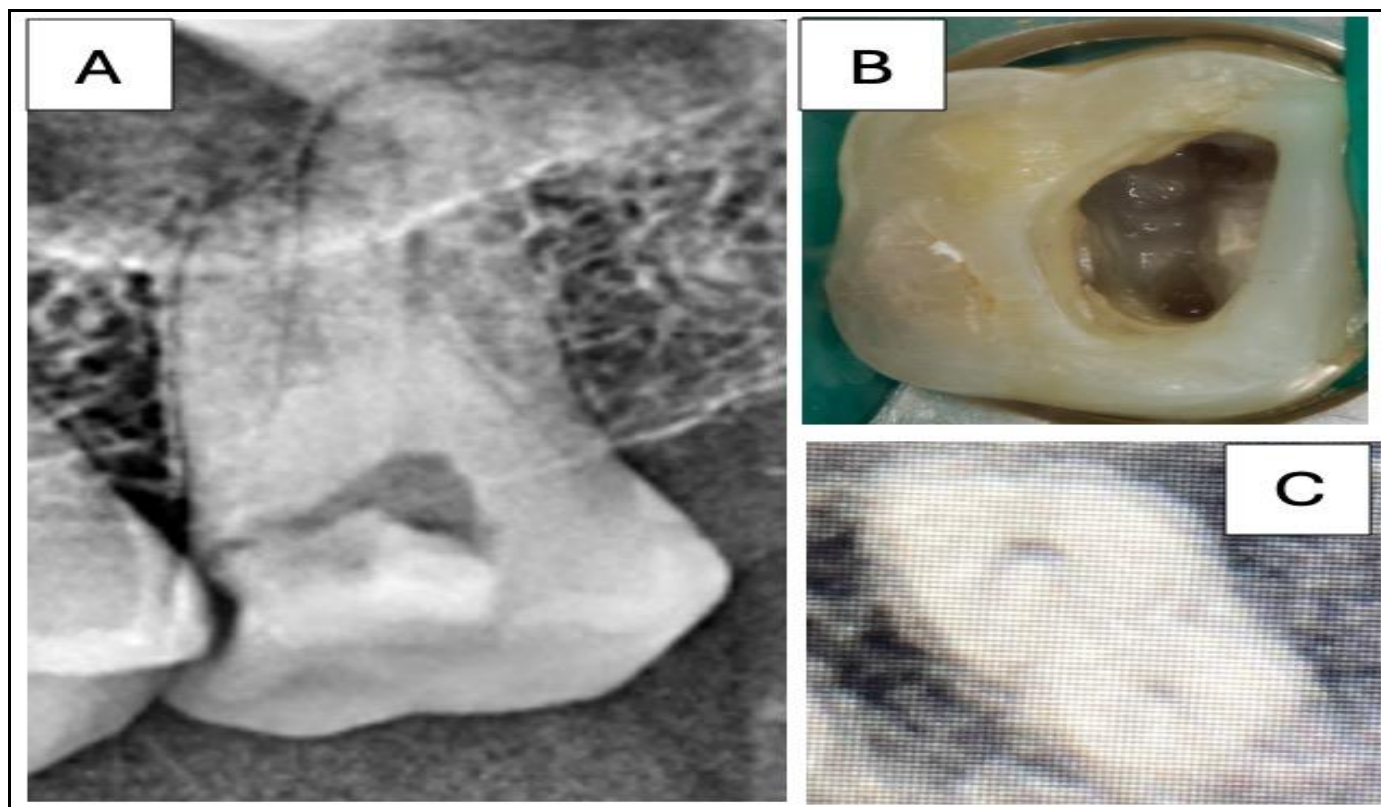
Pre-Operative. A: Intraoral Periapical Radiograph; B: Clinical Photograph of One Buccal and One Palatal Canal; C: CBCT Image
